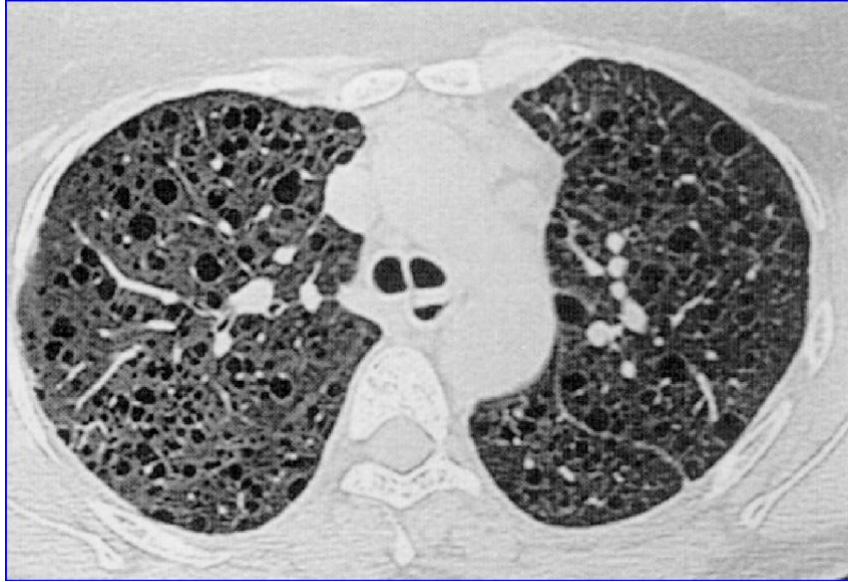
Chest CT scan of patient with lymphangioleiomyomatosis showing multiple cysts throughout the lung parenchyma.
